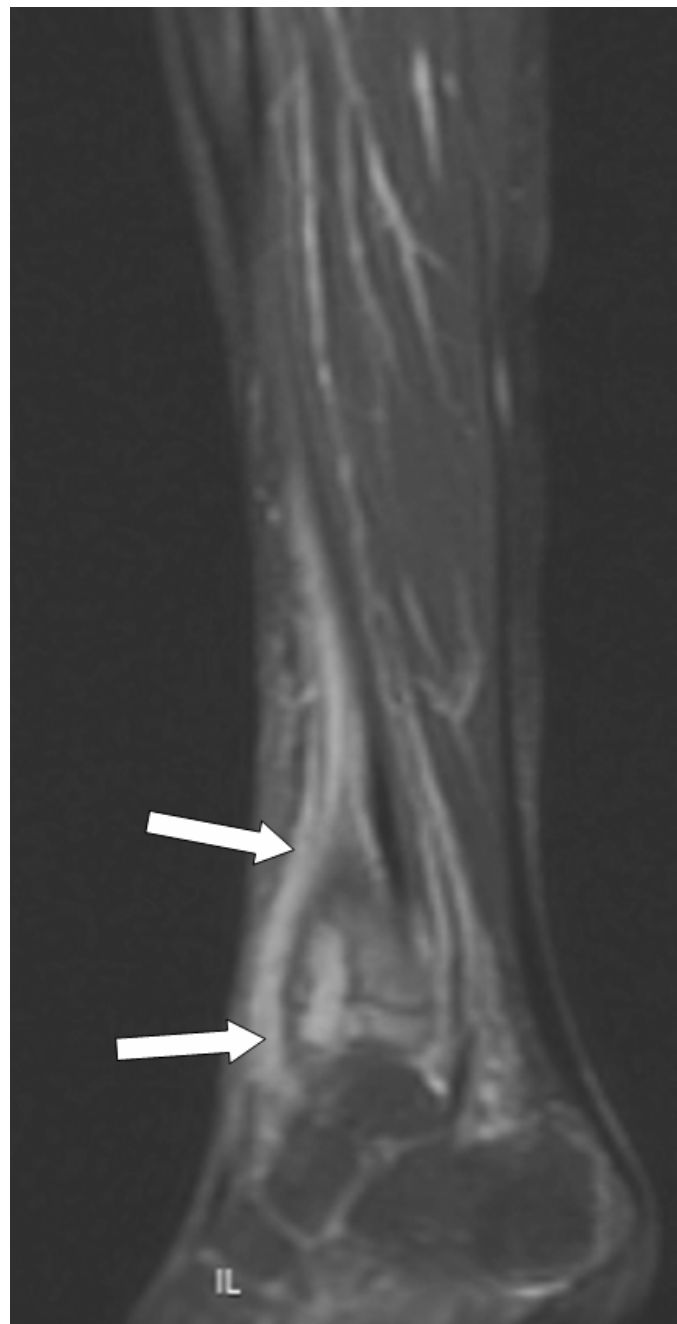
Oblique T1-weighted MR image after contrast. shows high-signal-intensity bone marrow edema (arrows) extending 5.5cm proximally along the distal tibial diaphysis from the site of the lesions.
